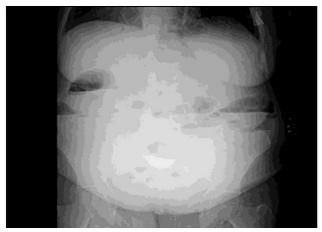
Air-Fluid Levels on Erect Plain Abdominal Radiograph
